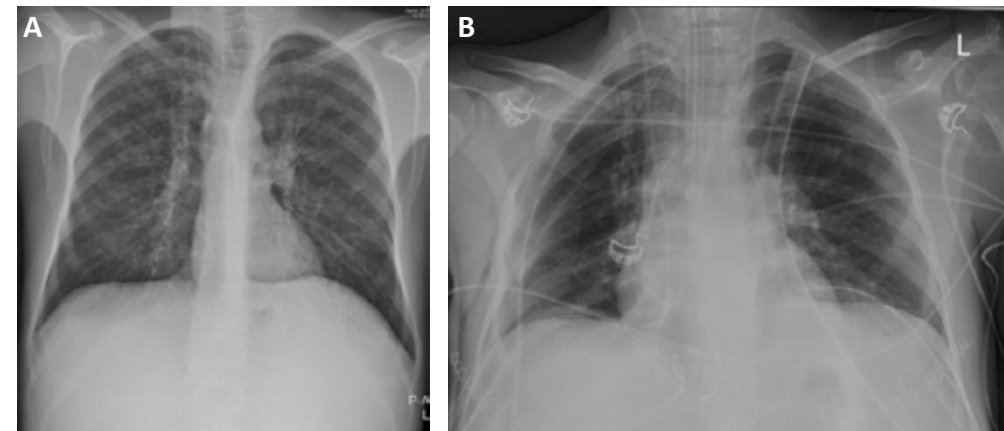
A: Recipient chest x-ray before transplantation. B: Recipient chest x-ray after transplantation
